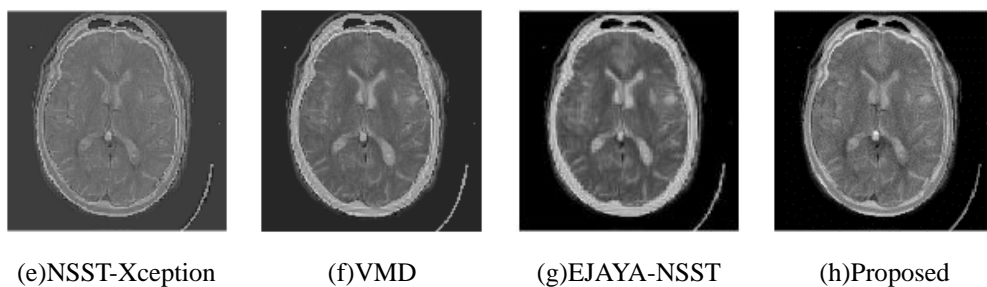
Qualitative outcomes of meningioma (CT-MRI-T2)
